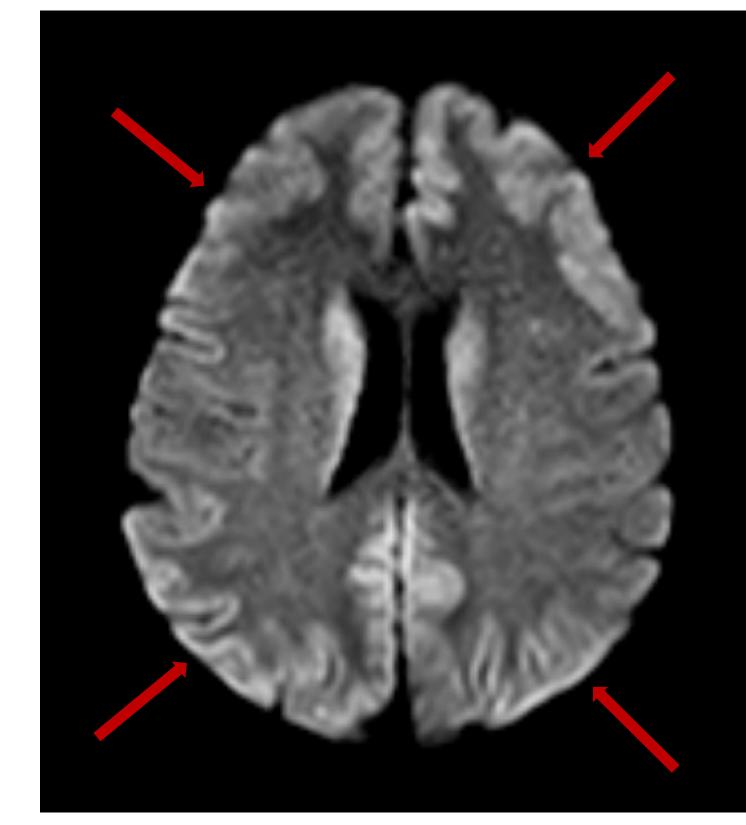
Diffusion weighted MRI image from 11/07/2023 showing hyperintensity ("cortical ribboning") throughout the bilateral cerebral hemispheres.
